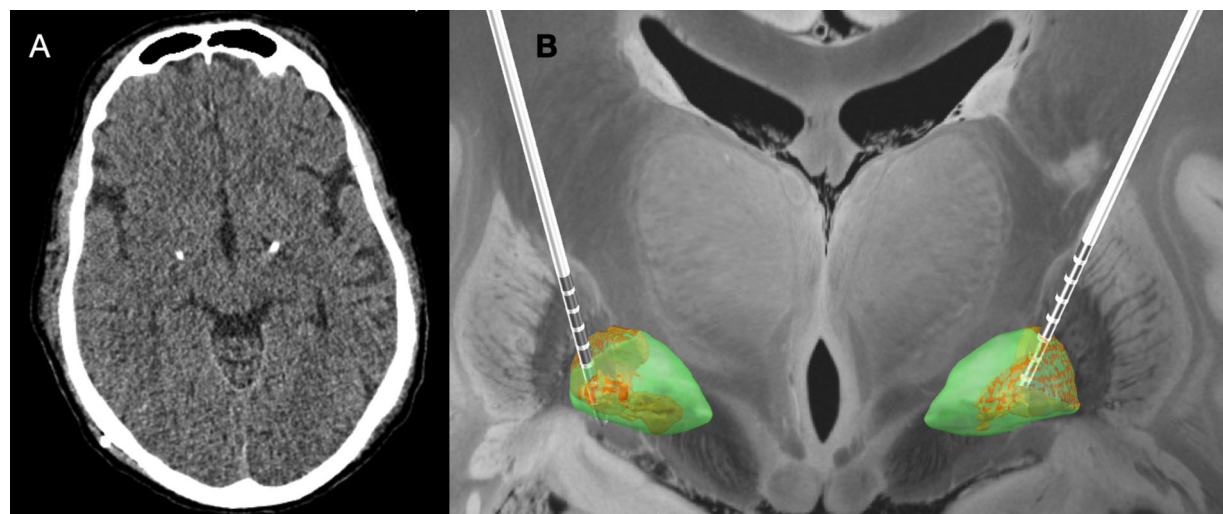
Postoperative imaging. (A) Postoperative computed tomography scan. (B) Reconstruction of electrodes in Montreal Neurological Institute space using LEAD-DBS software showing the lead inside the sensorimotor part (red) of the internal pallidum (green). Electrodes are projected onto a 7T brain atlas.¹⁰
